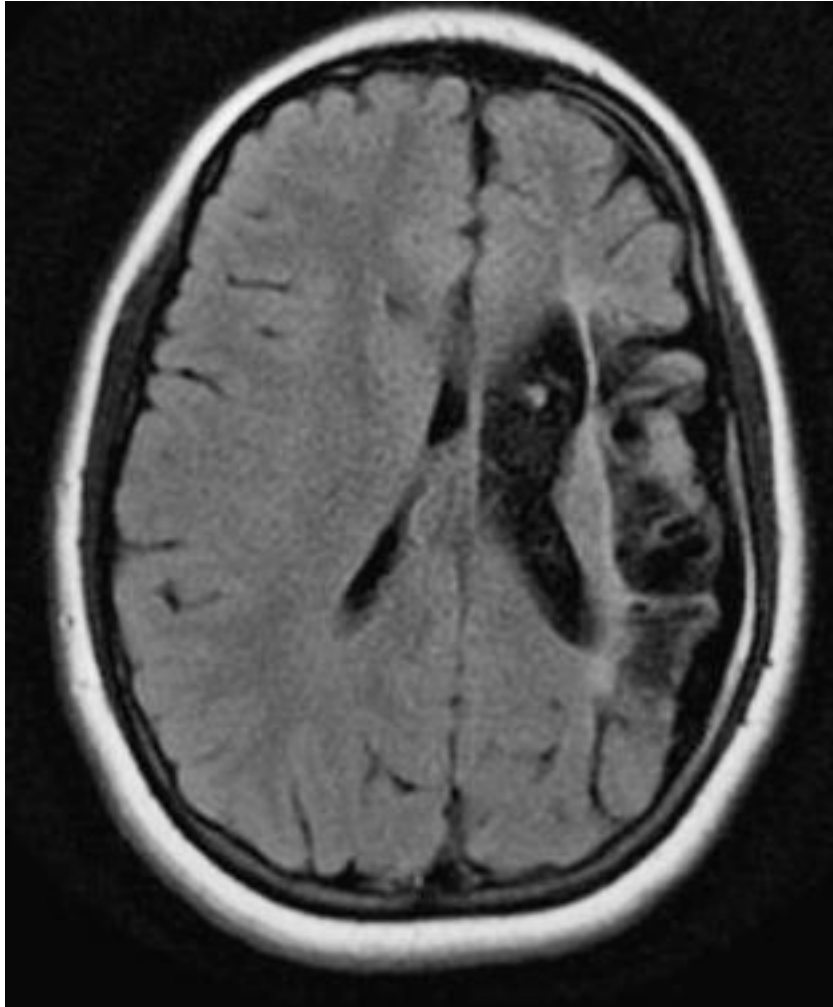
MRI brain revealed hemi-atrophy of left cerebral hemisphere. There is obvious atrophy of the left hemisphere, in the temporal and parietal lobes with enlargement of the adjacent subarachnoid spaces, frontal, temporal horns of the left lateral ventricle
